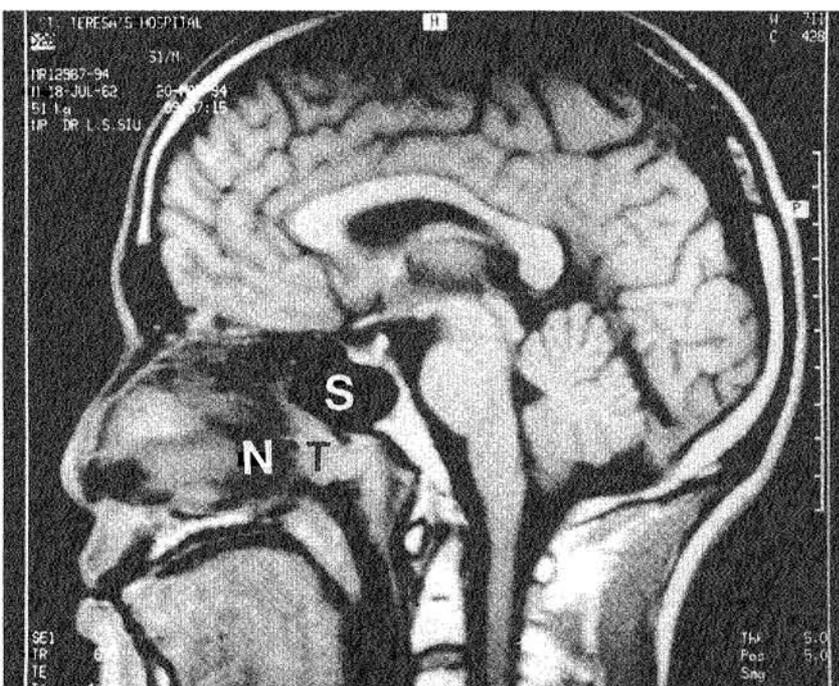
Magnetic resonance image in sagittal plane showing the tumour in the nasopharynx (T) below the sphenoid sinus (S) and involves upper part of nasal septum (N)
